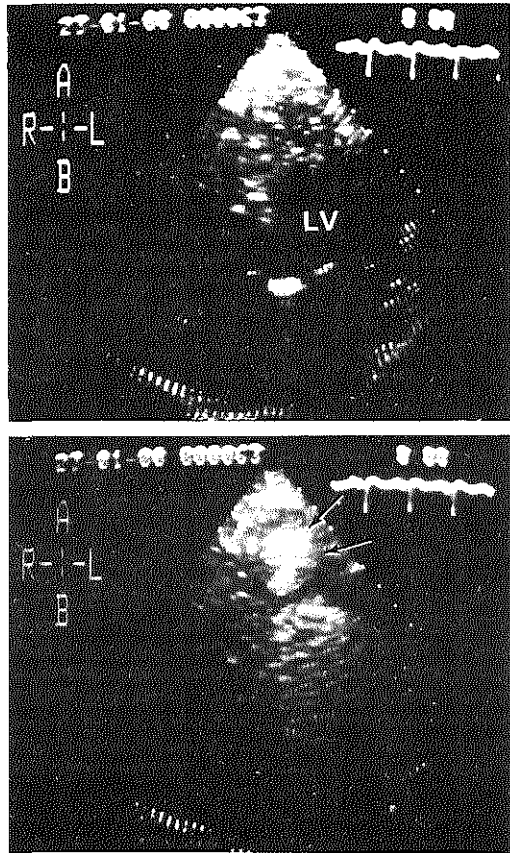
Apical four-chamber views of a patient with Loeffler's eosinophilia. Before opacification, the contour of the left ventricle cannot be appreciated because of non-structural echoes filling its cavity, mainly in the apical area (upper panel). After a pulmonary wedge injection of echo contrast, a bilobular shape of the left ventricular cavity is demonstrated (lower panel). A = apical; B = basal; R = right; L = left; LV = left ventricle.
